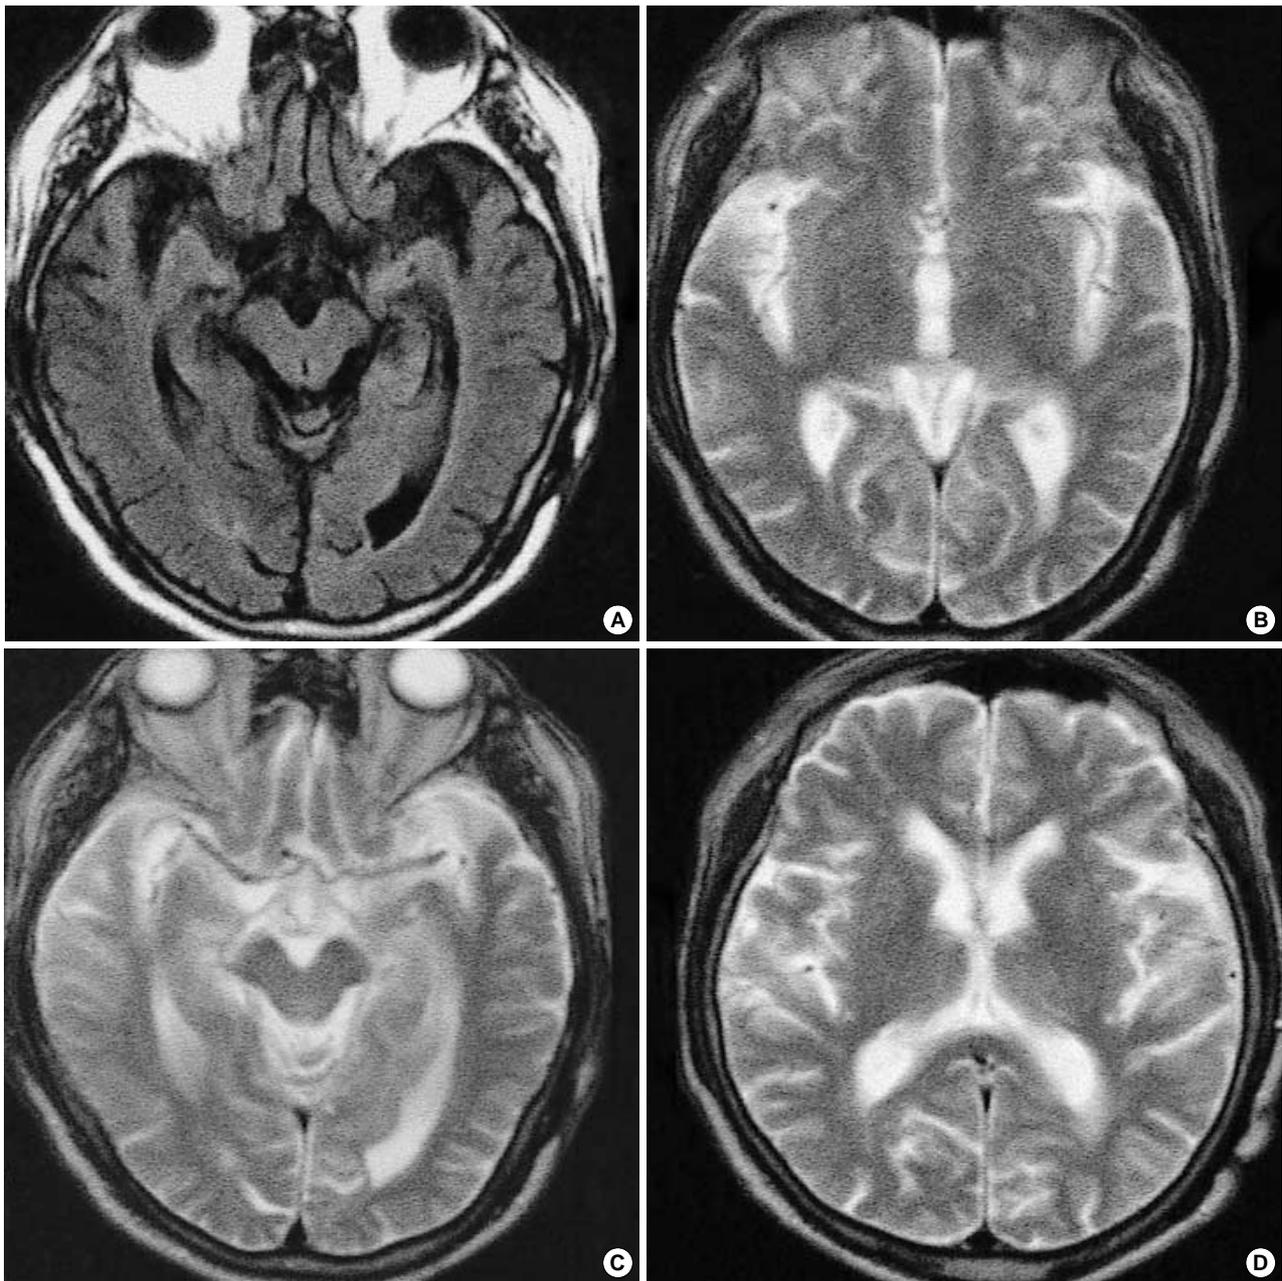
FLAIR (A) and T2-weighted images (B-D) revealed no chronic responsible lesions seen in Fig. 1.
